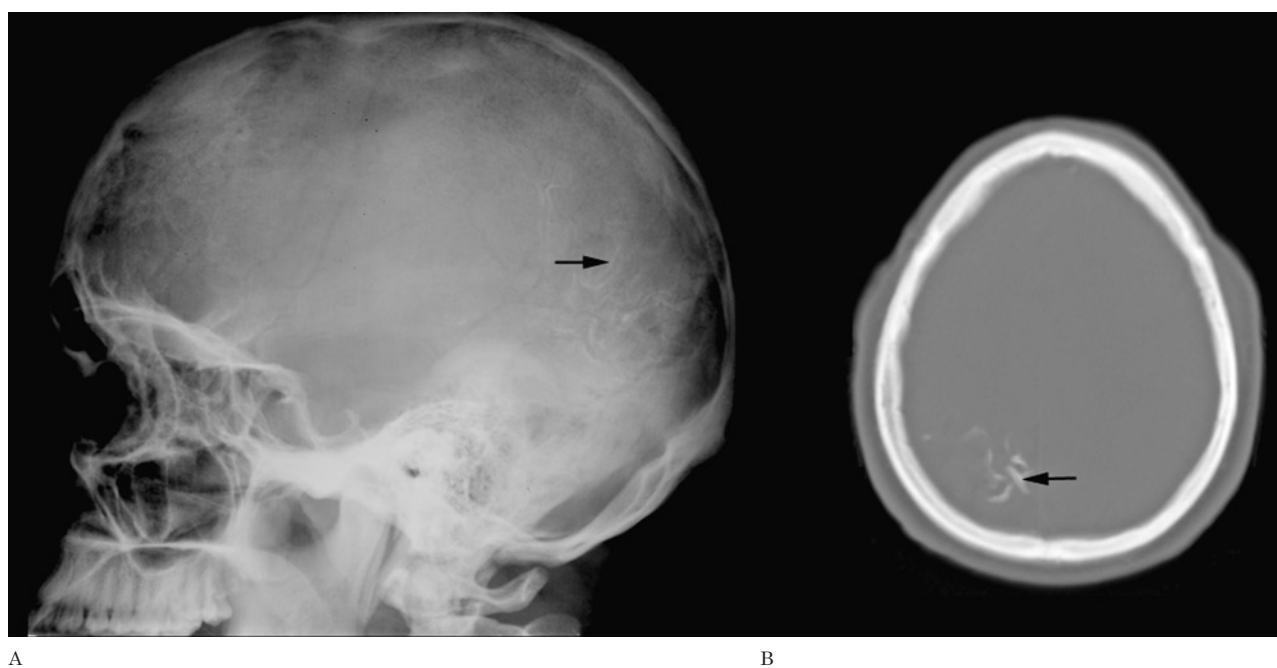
Sturge-Weber Syndrome. A) Plain lateral radiograph of the skull demonstrates the typical tram-track calcifications (arrow) in the occipital region. B) Nonenhanced CT scan of a different patient demonstrates the linear gyral calcifications (arrow) associated with this condition.
